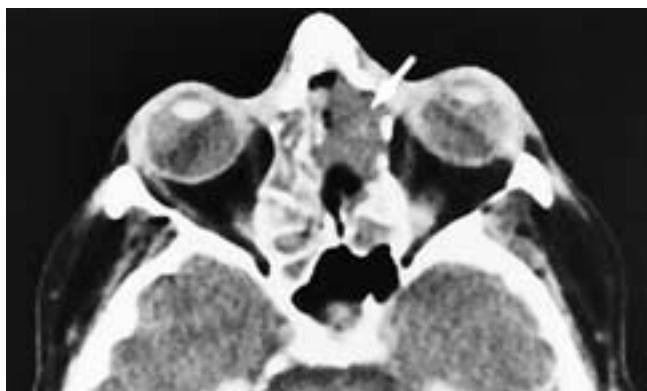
Axial CT scan shows the appearance of a left ethmoidectomy that has an accumulation of mucoid material within the postoperative cavity (*arrow*). Rather than extending into the left orbit as a typical ethmoid mucocoele, the postoperative mucocoele tends to fill the post-ethmoidectomy cavity first.
